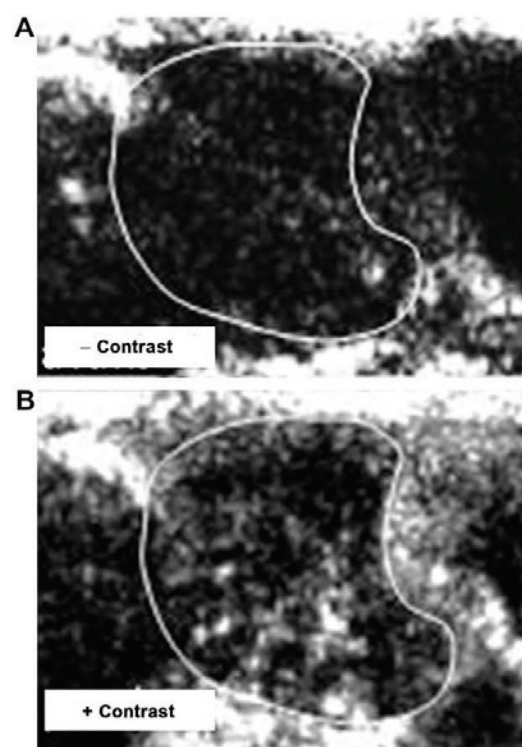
Contrast ultrasound to visualise vascularisation of a neuroblastoma (NB) orthotopic tumour. (A) NB cells injected into the right adrenal gland develop into a measurable tumour which can be visualised by ultrasound. (B) After intraocular injection of a contrast agent, vascular perfusion is visible and measurable.
